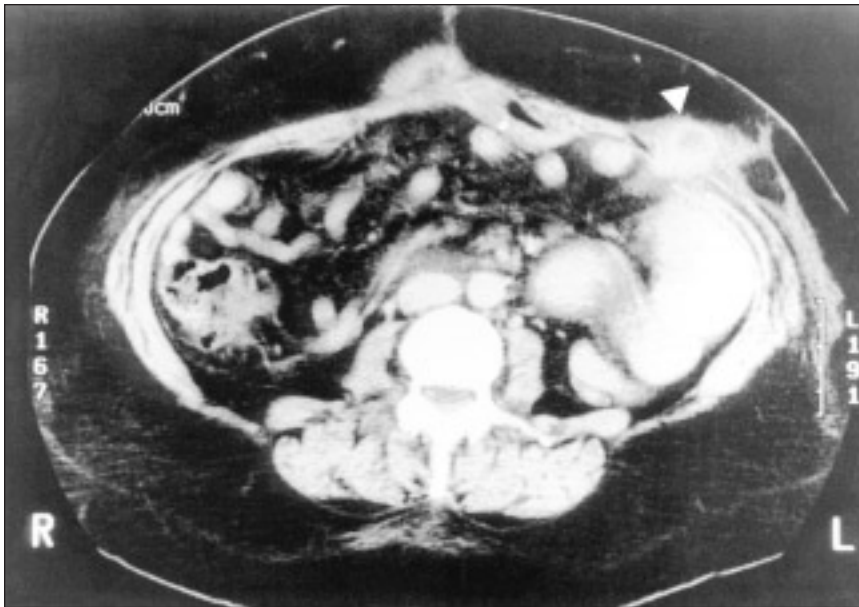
Computed tomography of the abdomen demonstrates a soft-tissue density (arrowhead), containing oral contrast medium protruding outside the fascia in the left upper quadrant. Proximal small-bowel dilatation is also seen.
